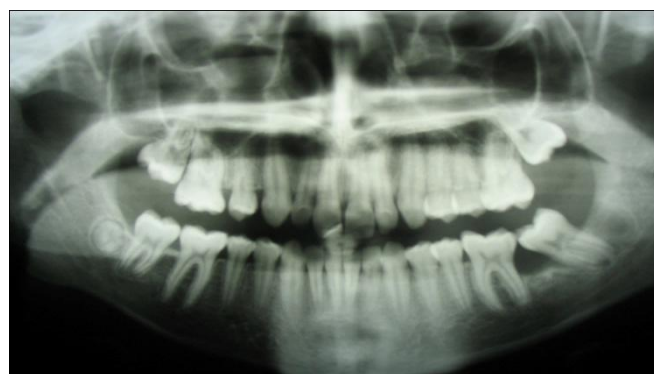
Orthopantomogram six month post operatively
